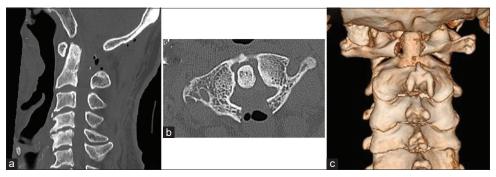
Postoperative mid-sagittal (a) and axial (b) image of computed tomography (CT) and three-dimensional CT (c) showing laminectomy of the atlas posterior arch.
